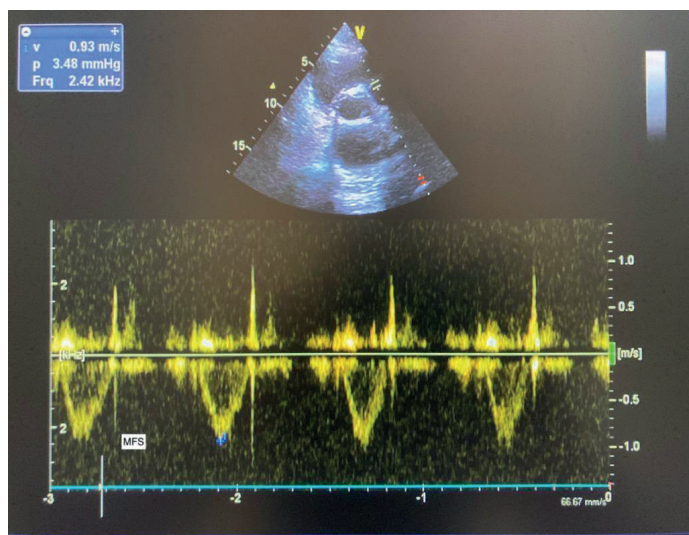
Echocardiographic image of MFS measurements
